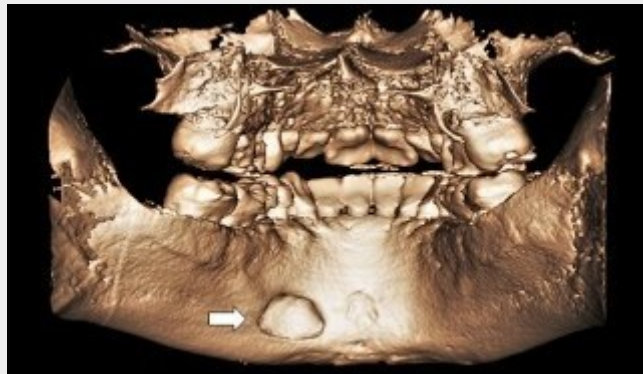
3D reformatted CBCT.
